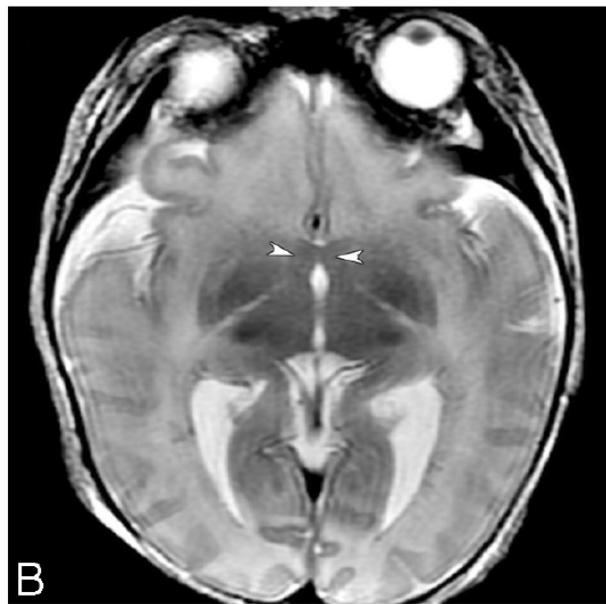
MR imaging of a 6-day-old term neonate initially diagnosed as having choanal atresia, vertebral anomalies, and coactation of aorta. *A*, Sagittal FSPGR image shows an area of fusion in the subcallosal region (*arrowheads*). *B*, Axial T2-weighted image shows the abnormal fusion in the same region (*arrowheads*). An azygous ACA is present in the anterior IHF. *C*, Axial T2-weighted image slightly superior shows thickened fornices (*arrow*) and partial fusion of the thalami. *D*, Coronal FSPGR image shows thickened fornices (*arrowheads*) and an area of fusion in the preoptic area (*arrow*).
